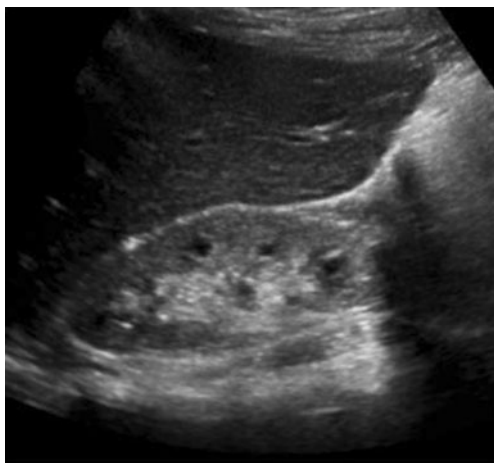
Renal ultrasound in nephronophthisis (NPHP). The renal ultrasound shows smaller bilateral kidneys, increased echogenicity (compare to abnormally lower echogenicity of liver), decreased cortico-medullary differentiation, and cortico-medullary cyst formation
